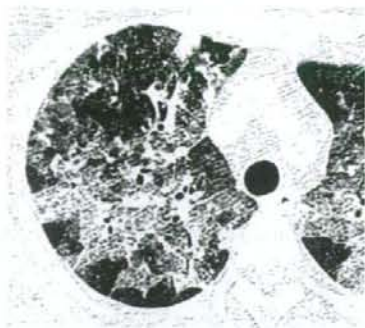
Type A ground glass opacity (GGO): GGO sharply demarcated from adjacent normal lung by interlobular septa. Methotrexate pneumonitis (MTX-P) was revealed in a 57-year-old woman who had received MTX therapy for 9 years for rheumatoid arthritis (RA). CT image shows homogeneous GGO which is clearly demarcated from adjacent normal lobules by interlobular septa.
